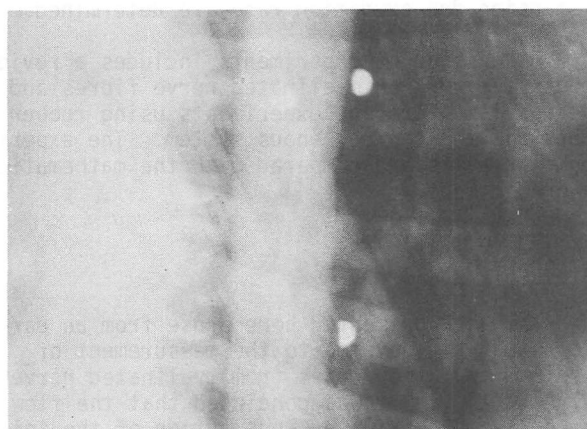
Roentgenogram print showing lead hemispheres on descending thoracic aorta.
